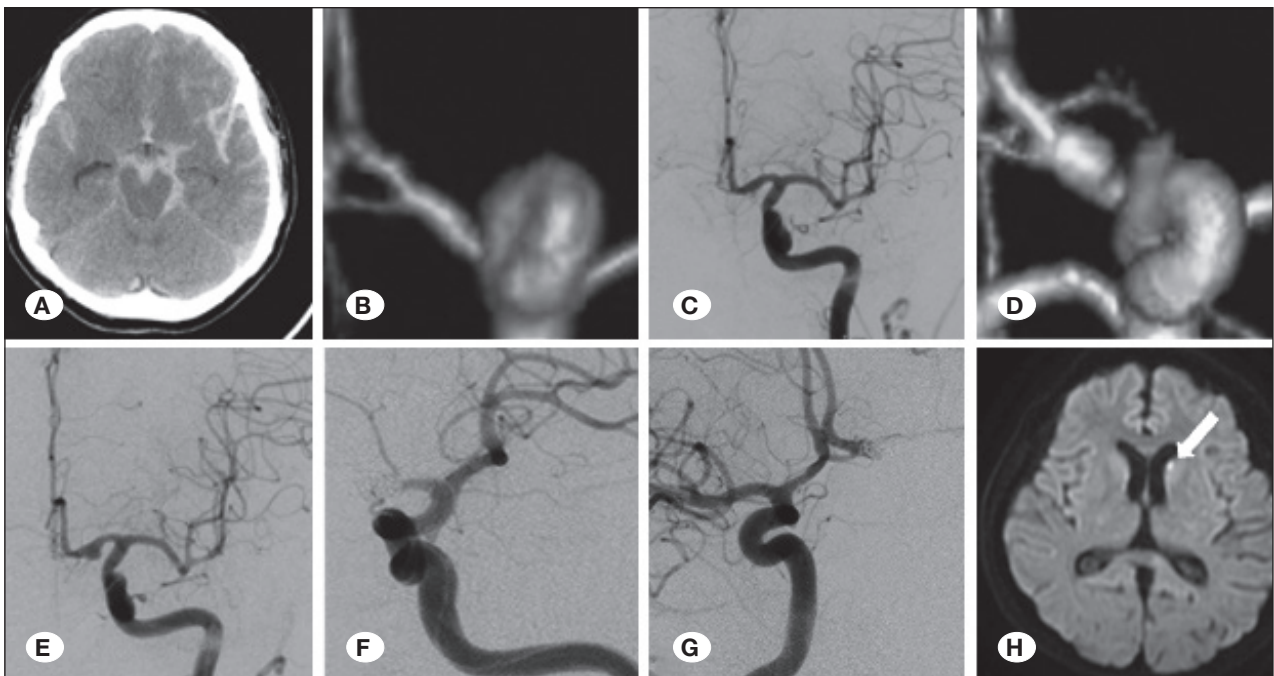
Endovascular trapping in Case 2. A) Initial CT reveals a diffuse SAH. B, C) Initial CT angiography and Anteroposterior view of the left ICAG show no significant abnormal vascular lesions. D) CT angiography performed on day 9 exhibits a left A1 dissecting aneurysm which had not been found in the previous angiography. E, F) Anteroposterior view of the left ICAG before and after endovascular trapping of the left A1 dissecting aneurysm. G) An anteroposterior view of the right ICAG presents good blood flow of bilateral A2 segments. G) Diffusion-weighted image on postoperative day 1 shows a new ischemic lesion in the left caudal head (white arrow).
